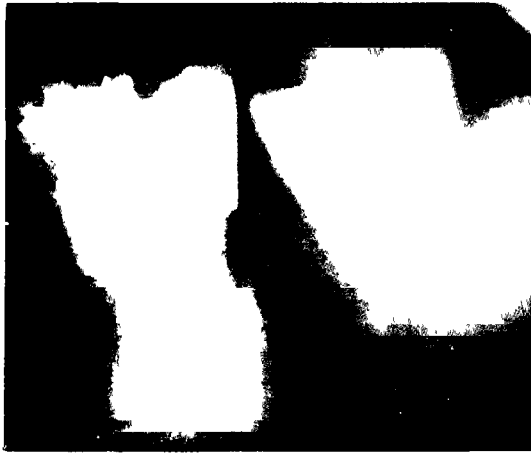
Pre-operative radiograph of 36 and 37
